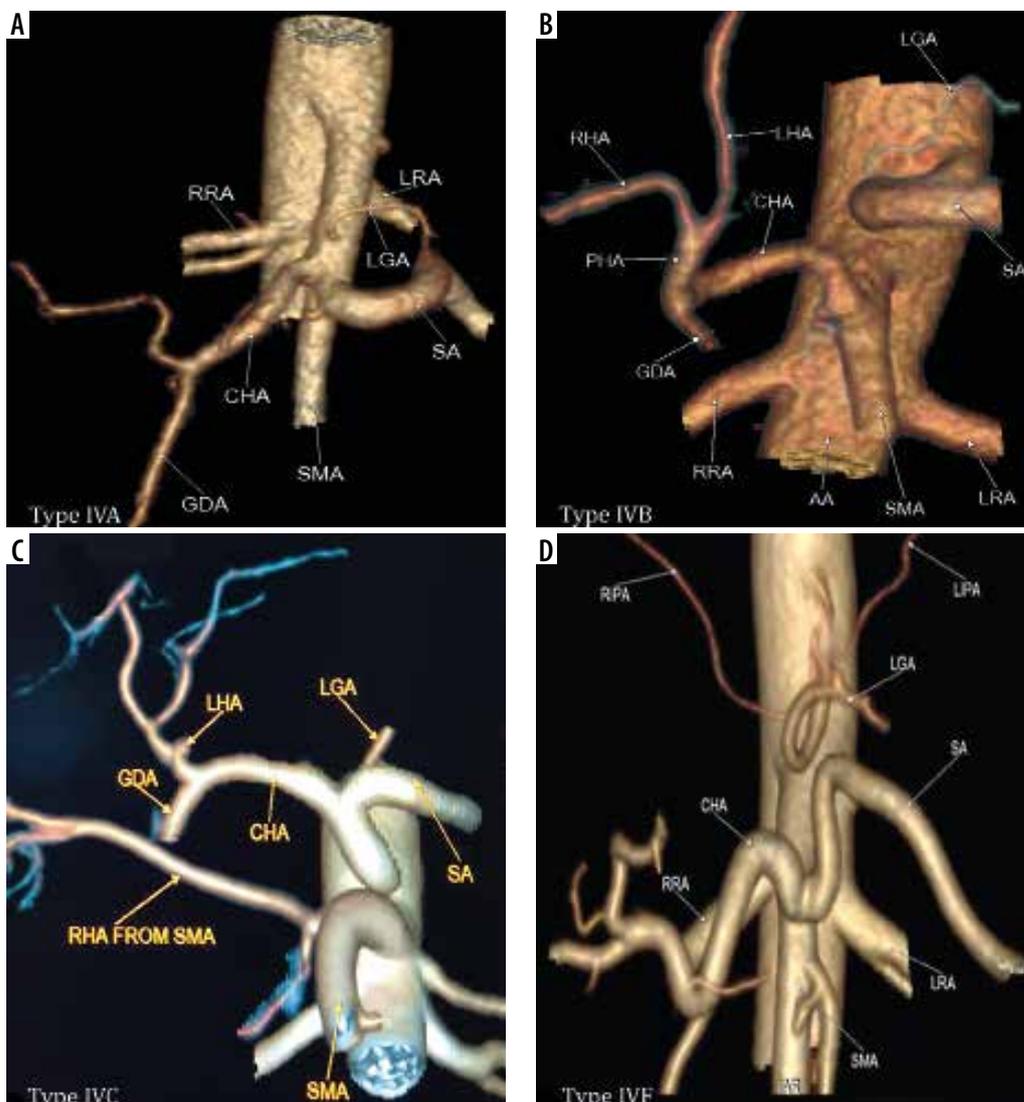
Computed tomography angiography images showing: A) celiomesenteric trunk (Type IVA) from the aorta, B) hepatomesenteric trunk (Type IVB) with left gastric artery (LGA) and splenic artery (SA) arising separately from the aorta, C) right hepatomesenteric trunk (Type IVC) from the aorta with left hepatic artery (LHA) from common hepatic artery (CHA), D) hepatospleno-mesenteric trunk (Type IVF) with LGA from the aorta
